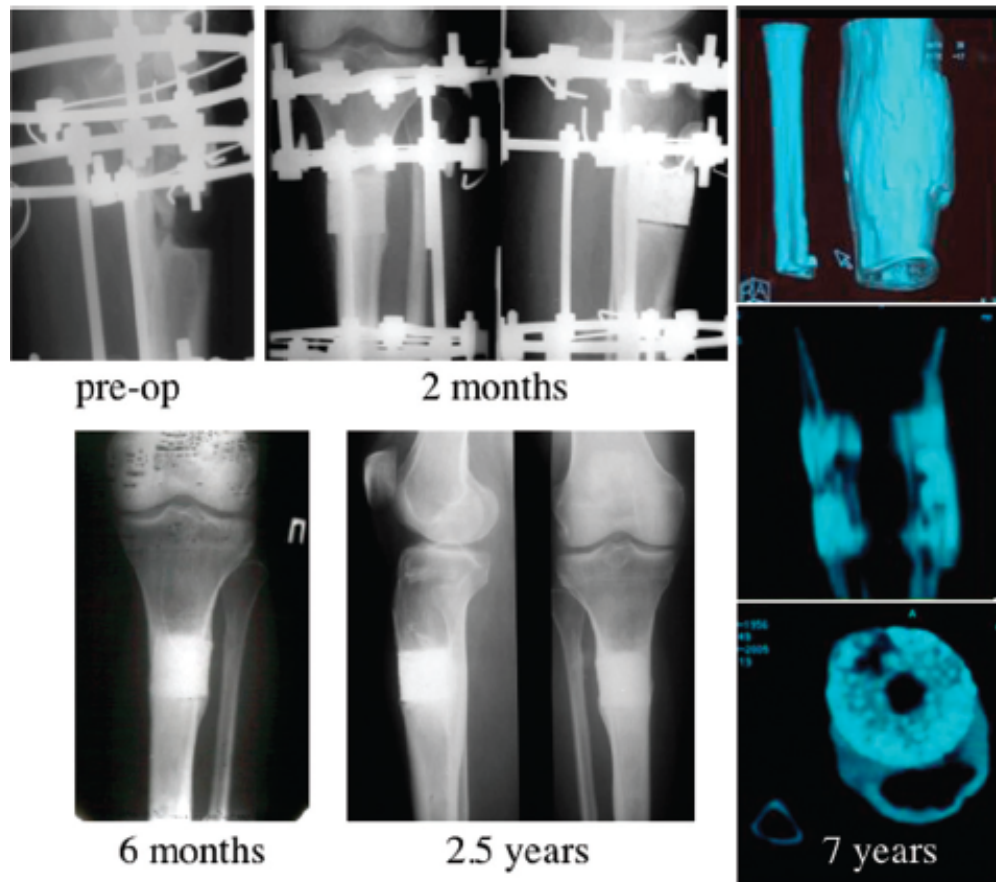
Bone tissue engineering using culture-expanded MSCs in humans. X-ray (gray) and CT scan (blue) of bone defect filled with culture-expanded hMSCs before and after surgery. The defect was the result of an unsuccessful bone-lengthening attempt. From Quarto et al.⁶²
